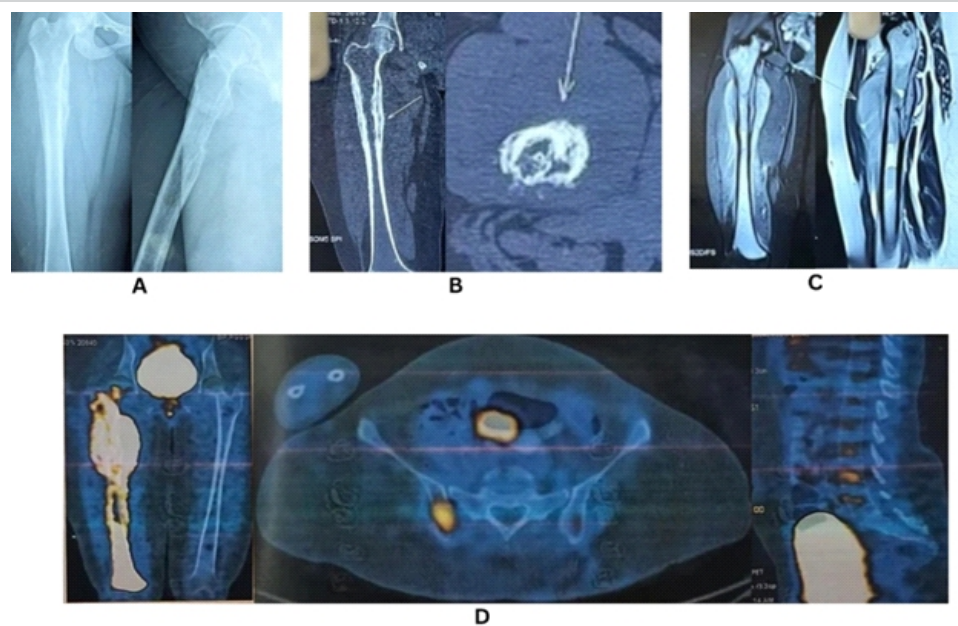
(a). X-ray showing a permeative osteolytic lesion with lamellated periosteal reaction in the meta-diaphyseal region of the right femur, (b) computed tomography demonstrating permeative lytic destruction with a wide zone of transition and lamellated periosteal reaction in the proximal right femur, (c) magnetic resonance imaging revealing abnormal marrow signal with cortical destruction, aggressive periosteal reaction, and surrounding soft-tissue mass in the proximal femoral shaft, (d) positron emission tomography-computed tomography showing a metabolically active expansile lytic lesion in the proximal and mid-shaft of the right femur with soft-tissue component, skeletal metastases, and metastatic right external iliac and inguinal lymph nodes.
